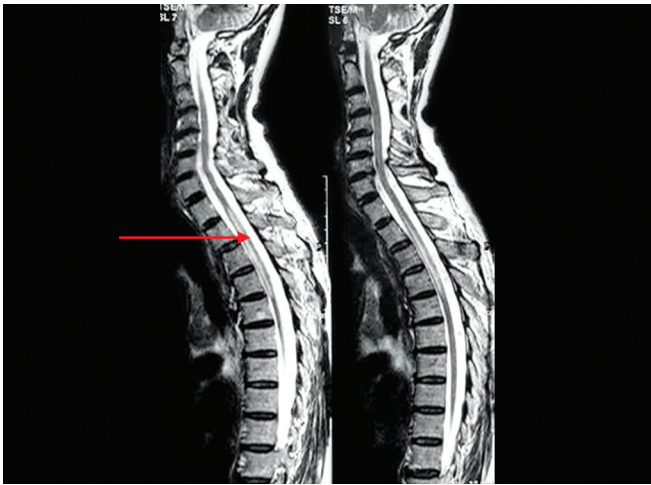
Magnetic resonance imaging (MRI) spine T2-weighted image shows altered signal changes (marked by red arrow) in the dorsolumbar spine characteristic of myelitis
